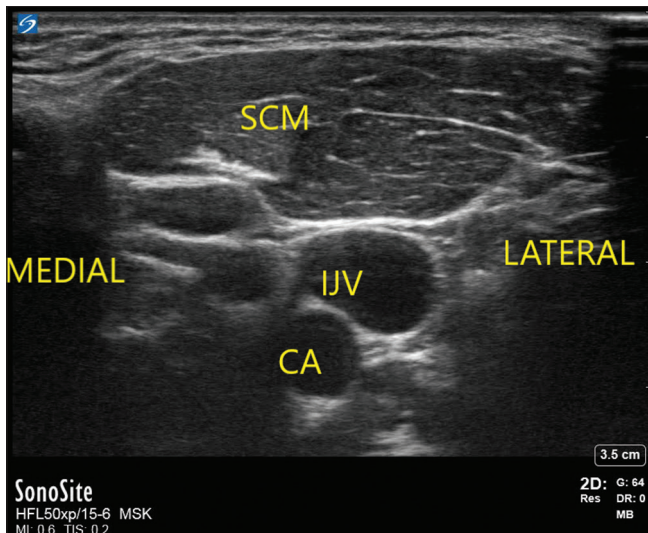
Ultrasonography of the sub-mastoid approach. SCM – Sternocleidomastoid; IJV – Internal jugular vein; CA – Carotid artery
